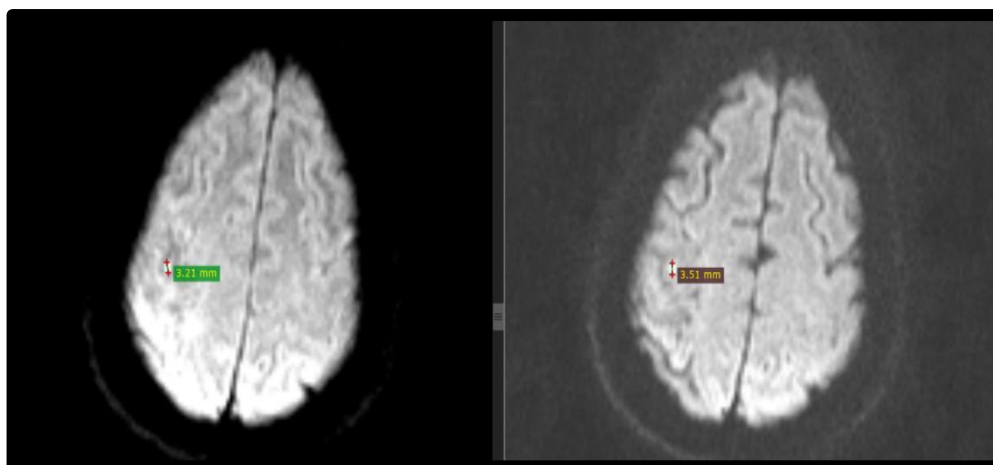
Sample MRI Image showing Measurement of Acute Stroke Lesion size on diffusion (b1000 & b2000)
